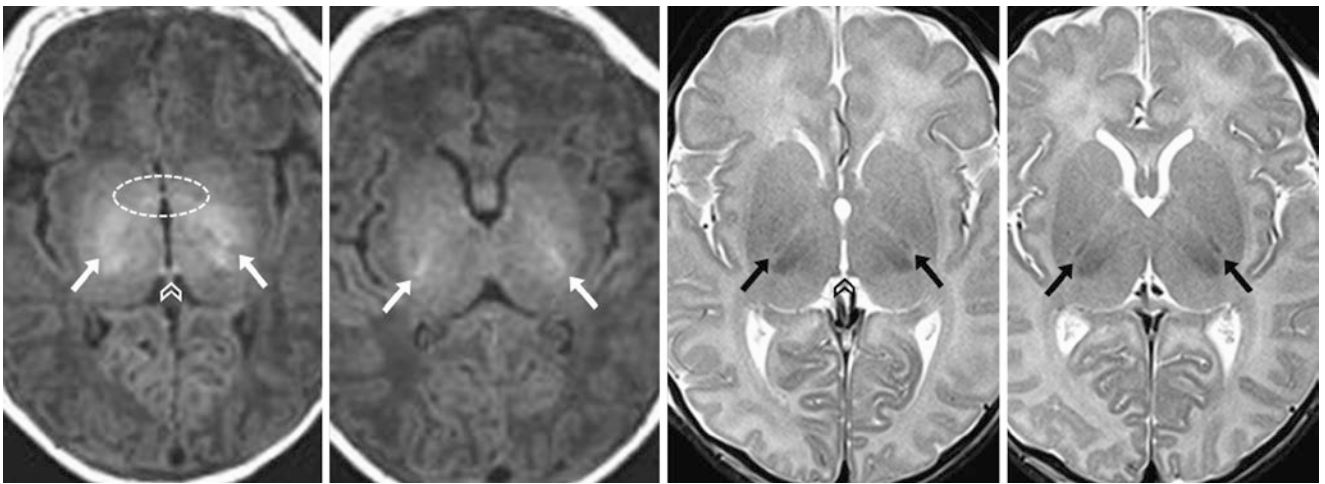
A 4-day-old term neonate had a normal 3T MRI with GE T1WI (left images) and SE T2WI (right images). The HC (chevrons) and PLIC (arrows) are better visualized on GE T1WI, but they appear
